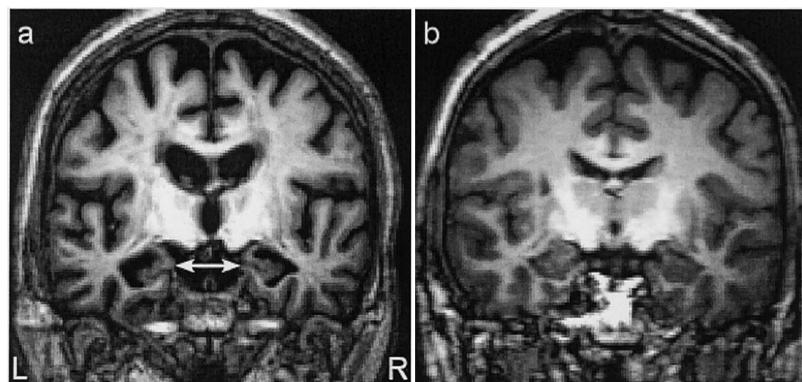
a: T1-weighted coronal images of patient T.E. b: An age-matched control participant oriented with the left side of the brain on the left side of the image. The location of the hippocampus is indicated by the white arrows. L = left; R = right.
